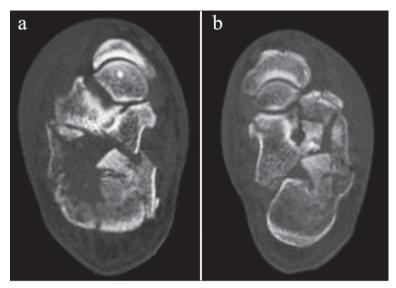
CT scan of both feet on admission showing severely displaced comminuted fracture of both calcaneus; a) right calcaneus fracture; b) left calcaneus fracture
